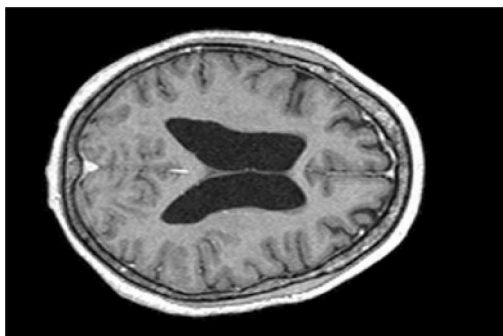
A transversal T1-weighted MRI experimental dataset of a normal brain.
